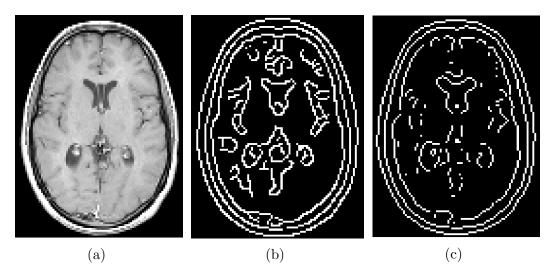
$128 \times 128$  MRI human skull slice (a) original gray-scale image (b) segmented image using canny edge operator (c) segmented image using Laplacian edge operator
